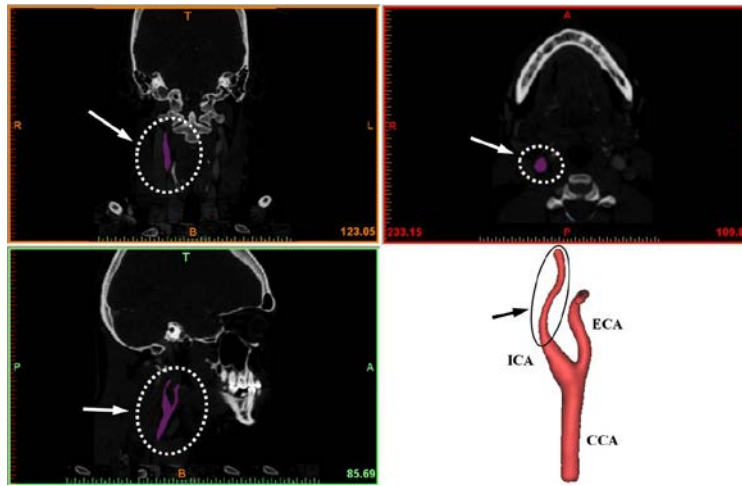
Different views of CT scan of carotid bifurcation: Partially stenosed ECA at bifurcation tip.
